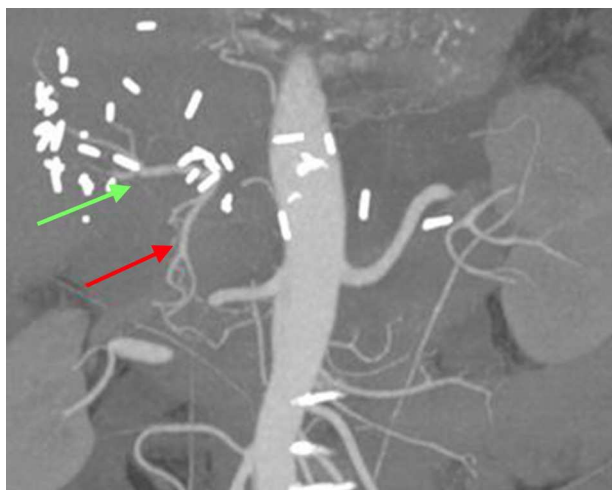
CT angiogram 15 days after surgery showing hepatic vascularization through the gastroduodenal artery (red) and proper hepatic artery (green).
